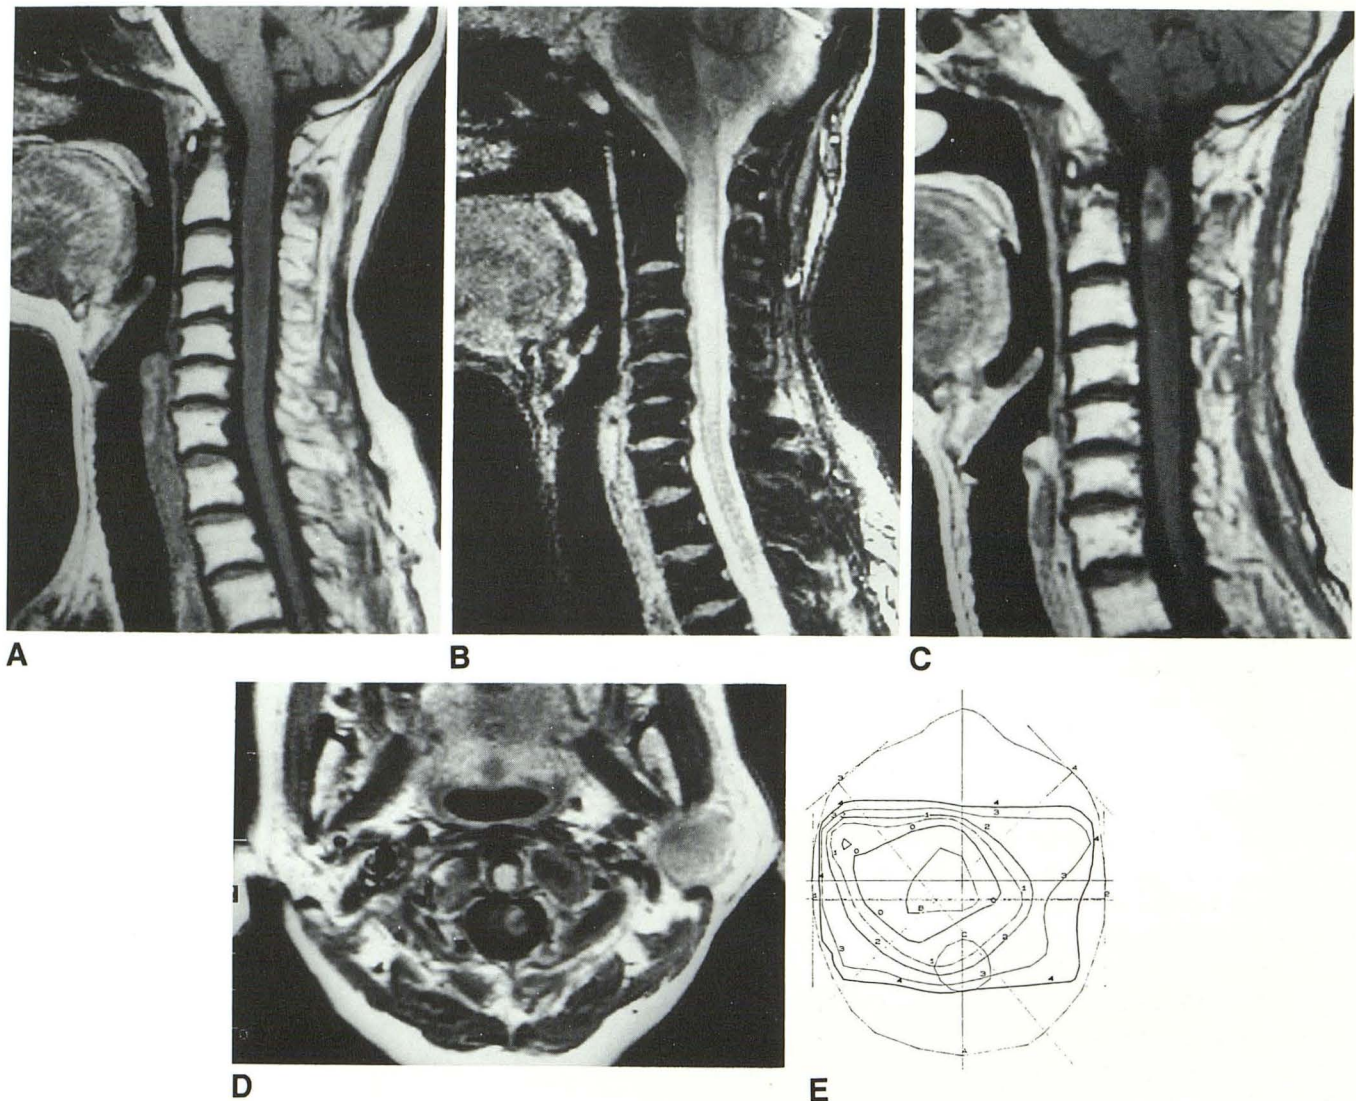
MR images of the cervical cord and isodose curve in case 4.
